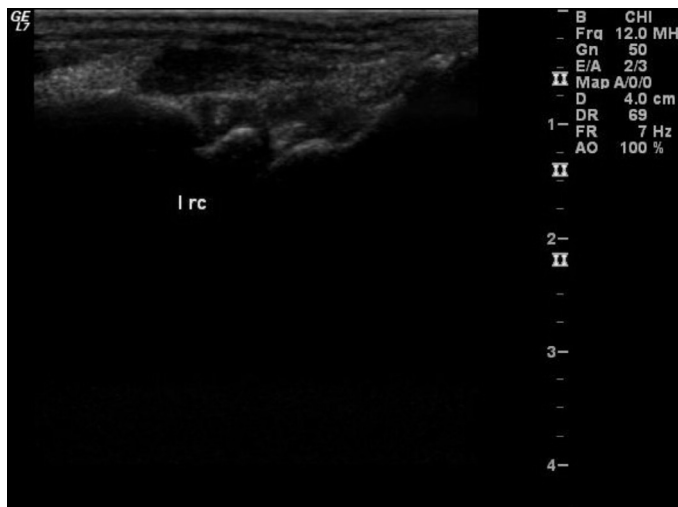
Ultrasound evaluation of the left radiocarpal joint and longitudinal scan of the patient showing effusion of the joint
